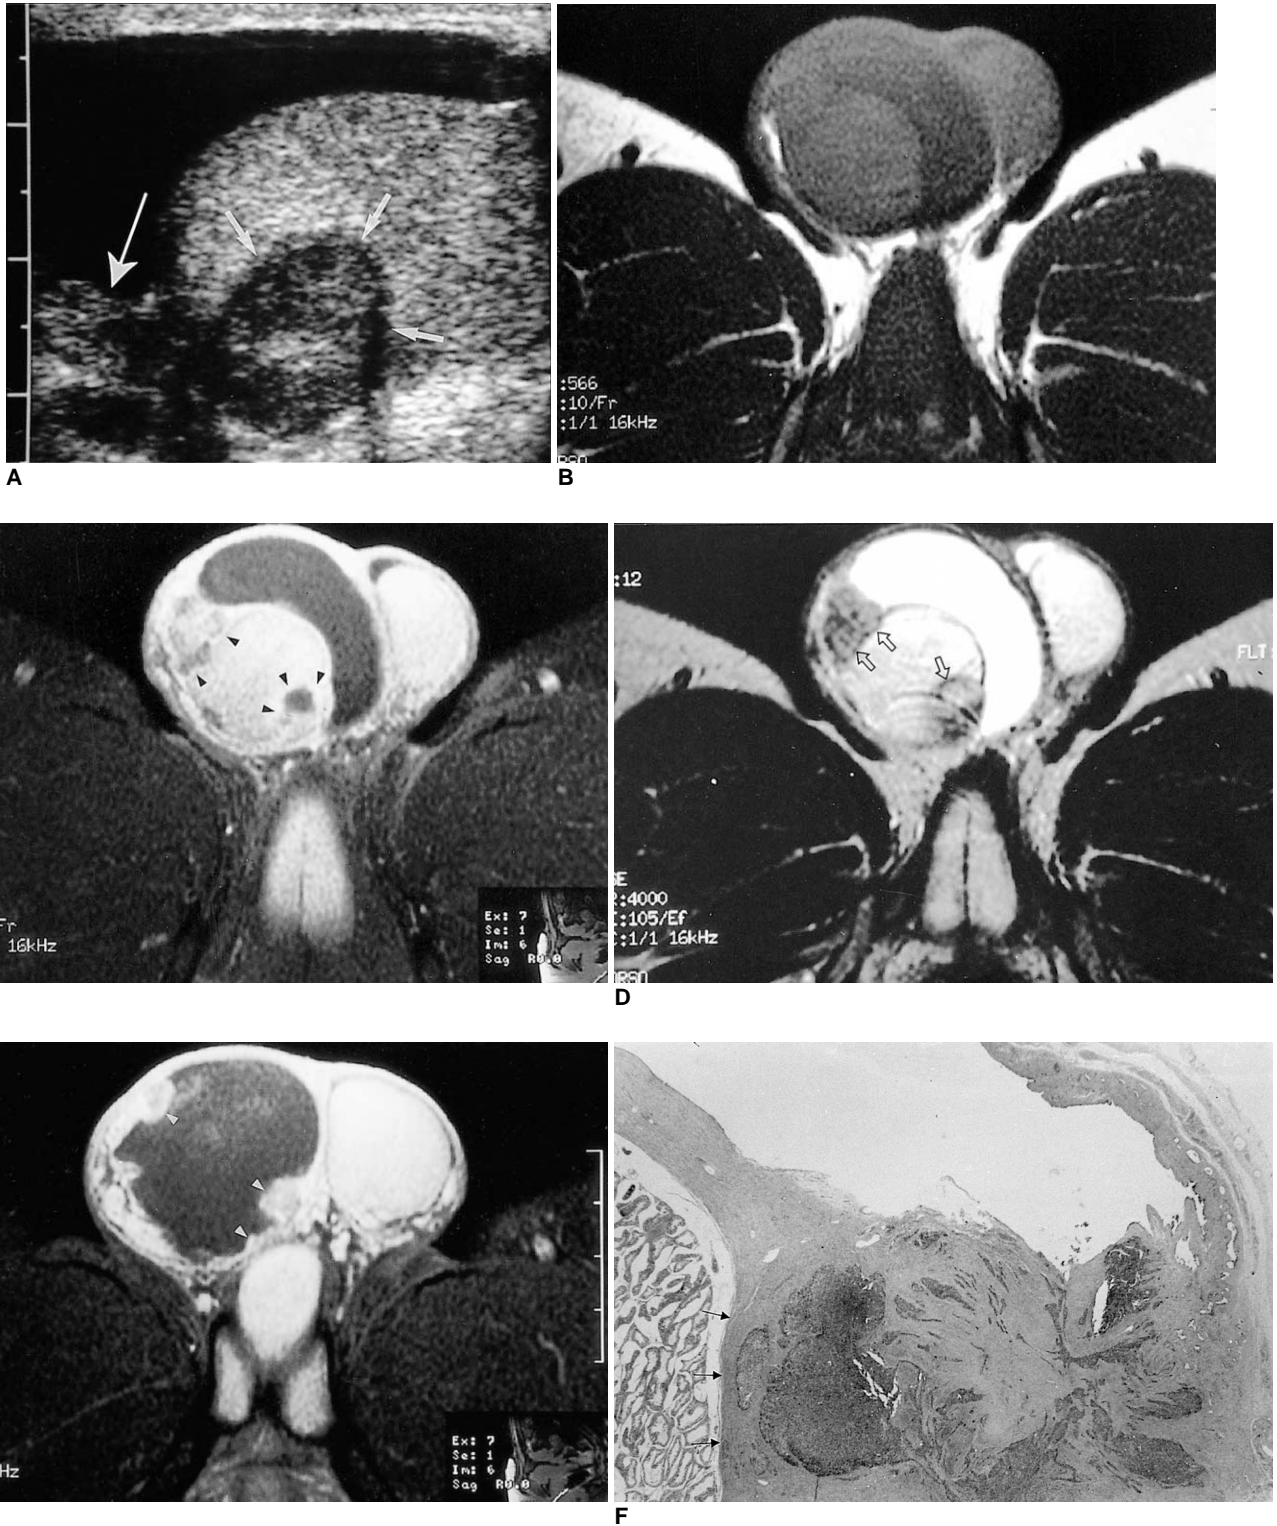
Axial MR images of the scrotum.
